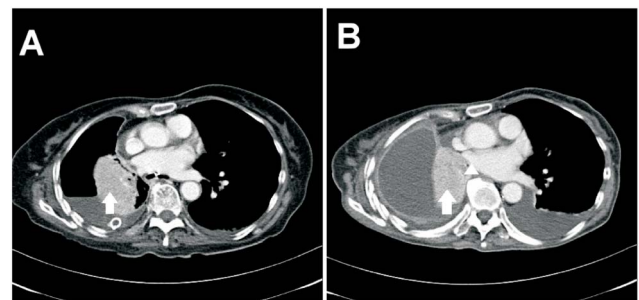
(A) Contrast-enhanced computed tomography of the chest shows persistent collapse of right lung after chest tube intubation (arrow). (B) Contrast-enhanced computed tomography of the chest, performed 4 months after the operation, reveals a contrast-enhanced carcinoma over the right lung (arrow) and tumor invasion to the mediastinum (arrowhead)
